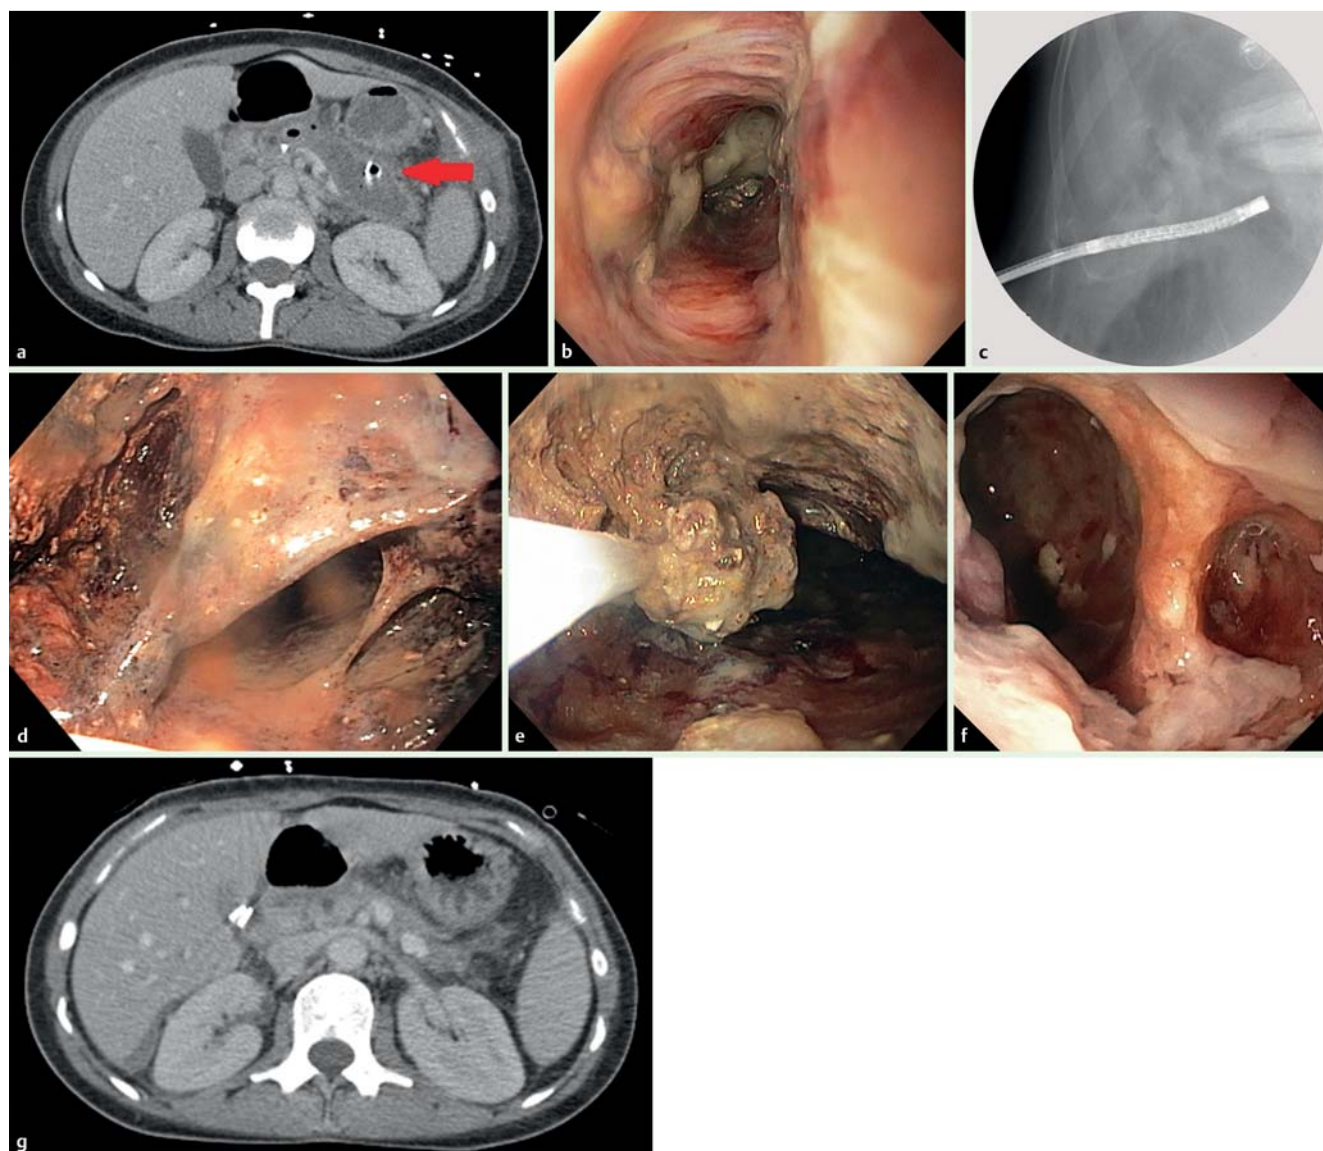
a Axial CT scan with WOPN (red arrow) with percutaneous drain in place. b Endoscopic image of sinus tract. c Fluoroscopy of percutaneous endoscope accessing WOPN via sinus tract. d Initial visualization of necrotic cavity prior to debridement. e Removal of necrotic material with polypectomy snare. f Endoscopic image of necrotic cavity after debridement. g Follow-up axial CT scan 9 months after direct percutaneous endoscopic necrosectomy demonstrating complete resolution of WOPN.
